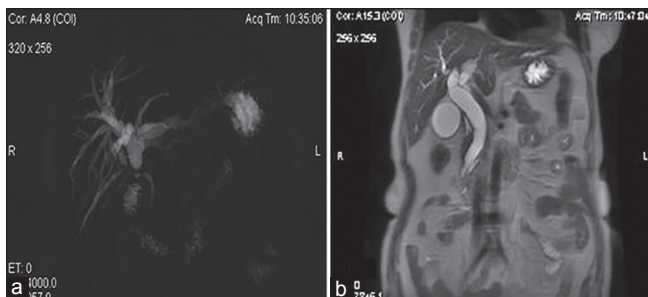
Magnetic resonance cholangiopancreatography image showing postcholecystectomy mid-common bile duct (CBD) benign stricture (a) and coronal T2-weighted image showing benign biliary stricture at terminal CBD (b)
